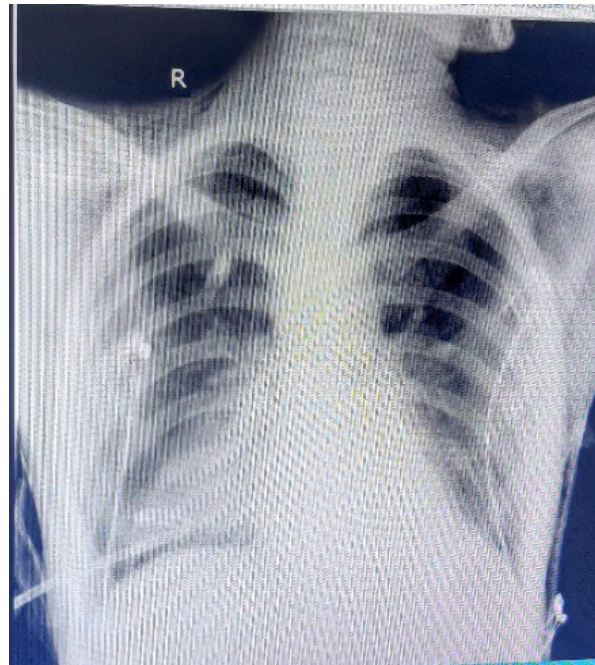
Chest x-ray- homogenous opacity in right lower zone
